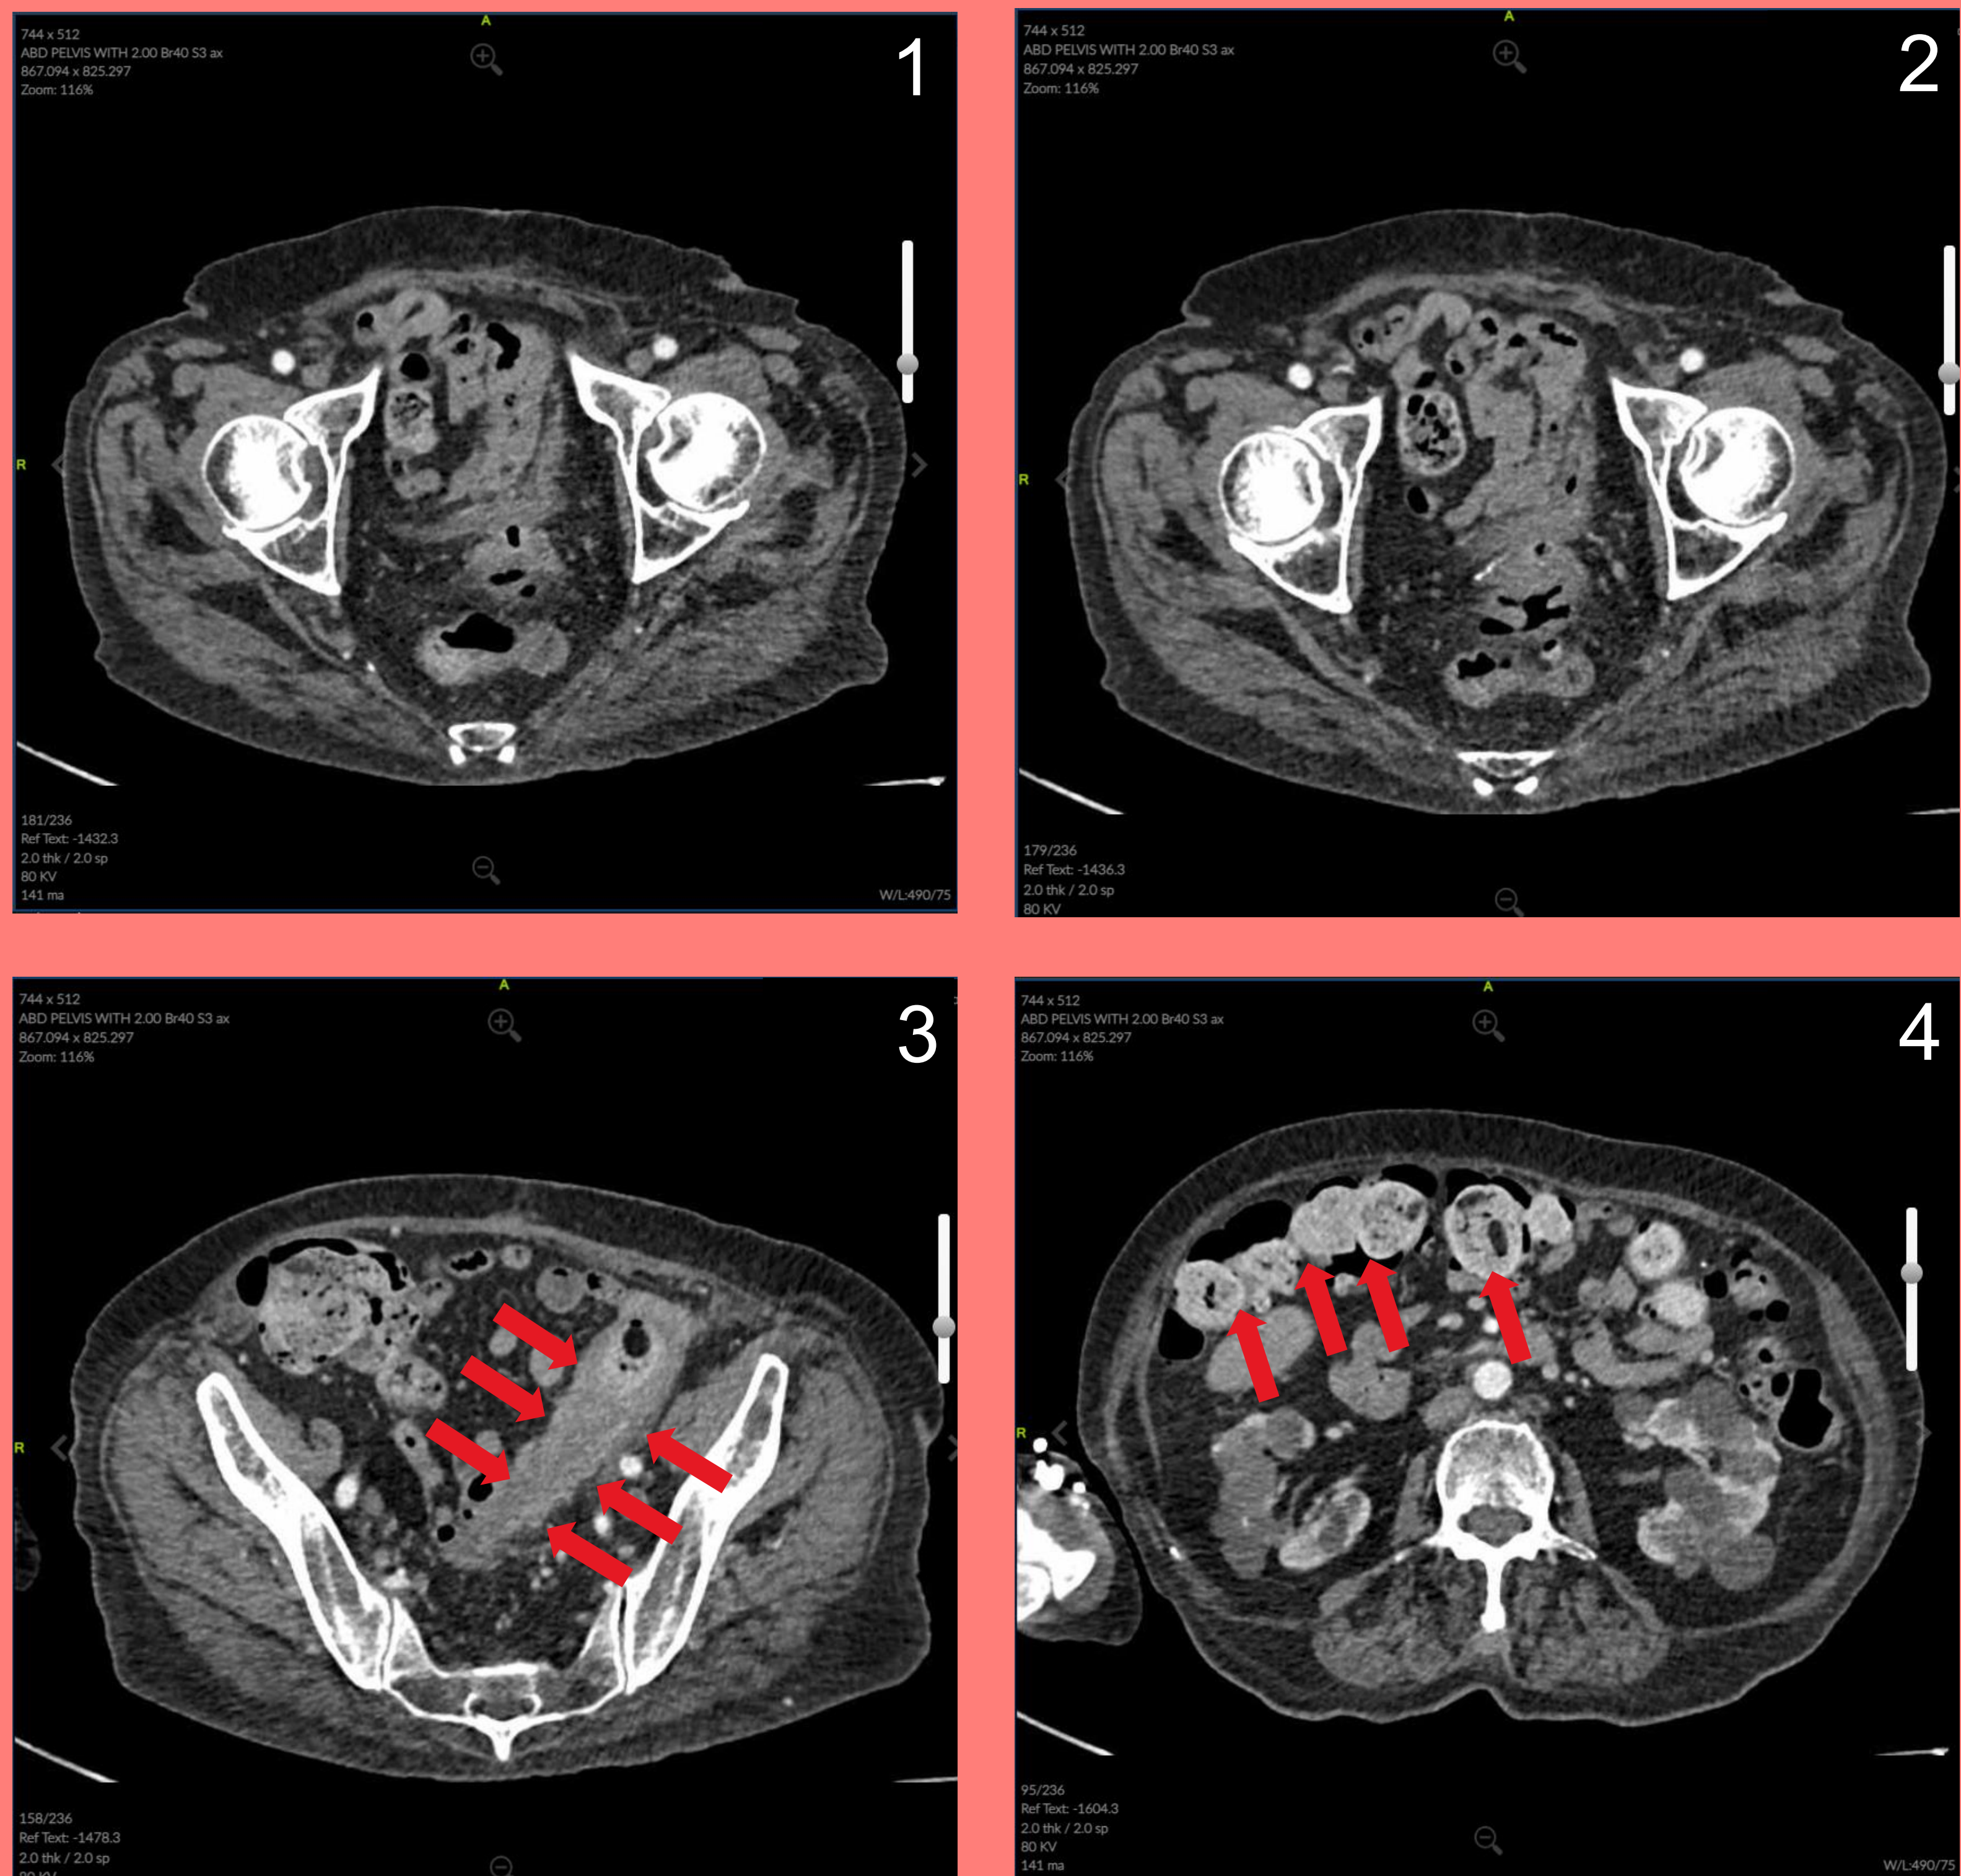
CT of air in the vagina which is considered a normal finding since it is an open environment
